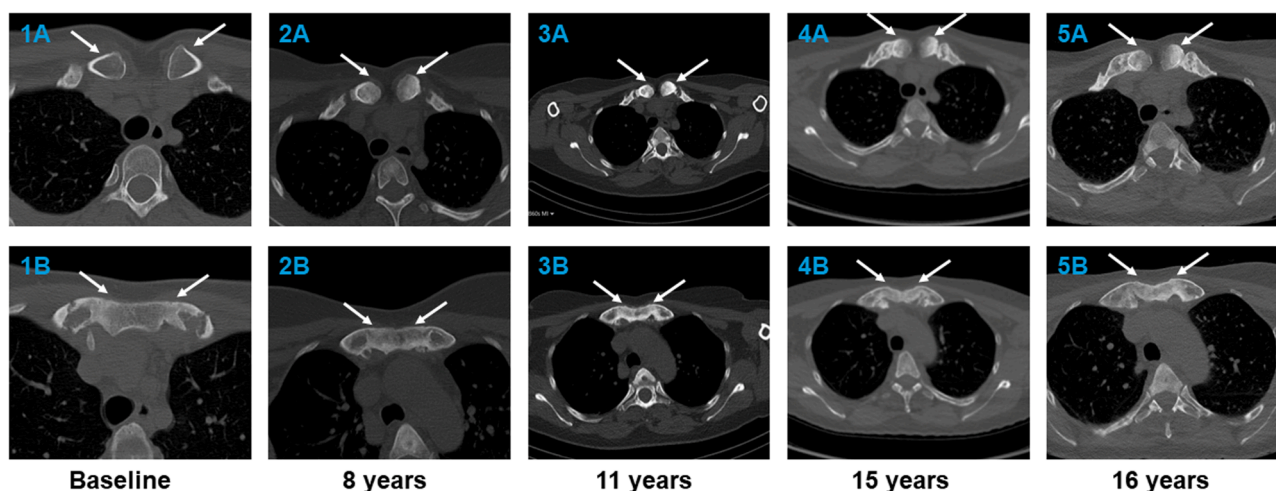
Axial plane of computed tomography (CT) images from de SPECT-CT of a representative female adult CNO patient visualizing the radiologic progression of anterior chest wall lesions in the context of treatment over time.
